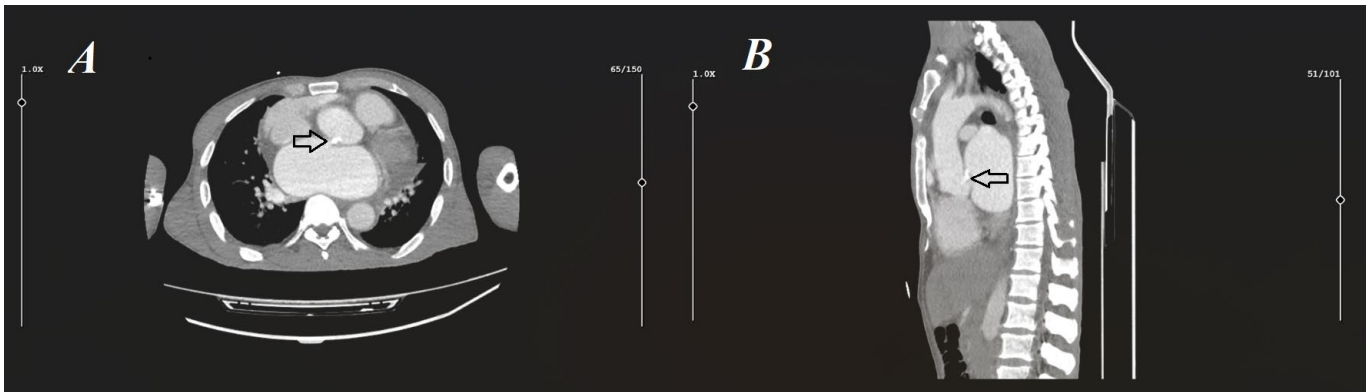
Contrast-enhanced computed tomography revealing calcification at the level of the sinus of Valsalva, irregularity of the sinus of Valsalva wall, and a fistula extending from the aorta to the left atrium.
